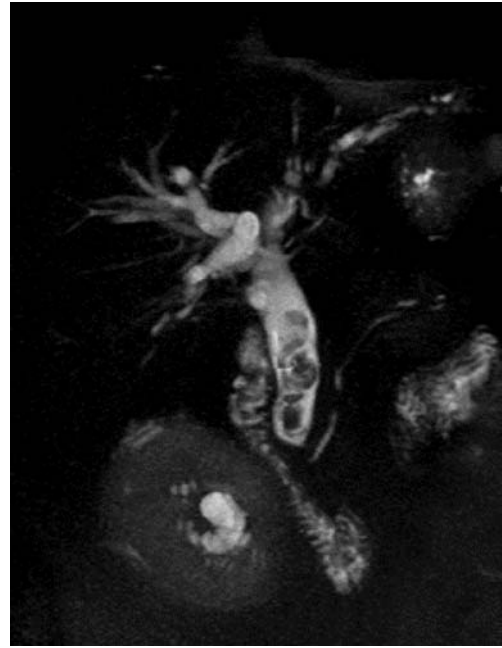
T2-weighted abdominal study with relaxation-time-related fat suppression technique acquired with a half-Fourier acquired single-shot turbo spin echo with inversion recovery preparation (HASTE with IR=HIR) after administration of a paramagnetic contrast agent. Acquisition time per slice was 1.2 s. Effective echo time was 57 ms. Inversion time was 150 ms. Spatial resolution was  $1.9 \times 1.4 \times 8$  mm
